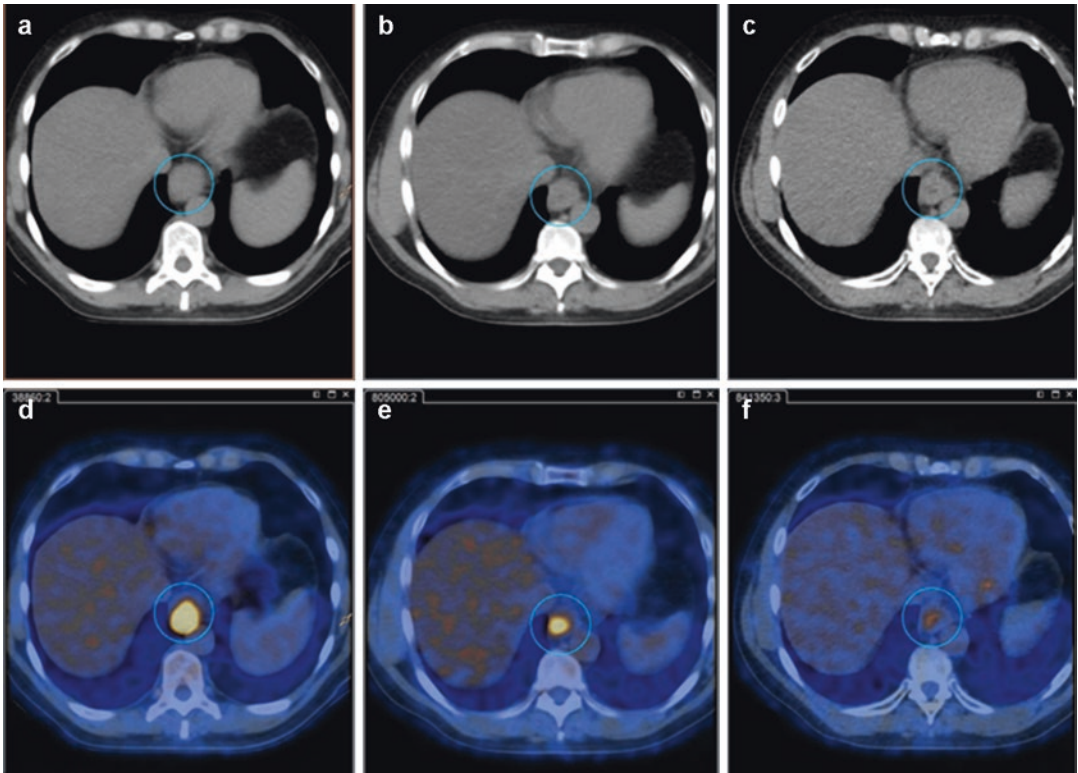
Complete response to CRT. CT and PET/CT images before (a, d), during (b, e) and after (c, f) treatment. At pre-treatment images EGJ cancer is a large lesion with initial SUVmax 14 (a, d). After inductive chemotherapy (b, e) there is only a small decrease in volume, but a
